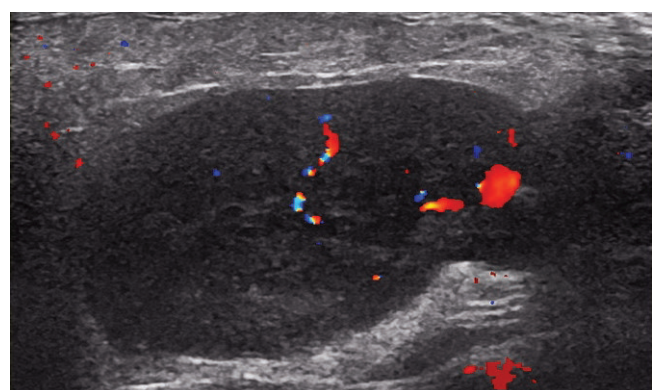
The color Doppler sonographic image shows a solid, hypoechoic, homogeneous lesion with mild internal vascularity in the parotid gland, a Warthin's tumor.
